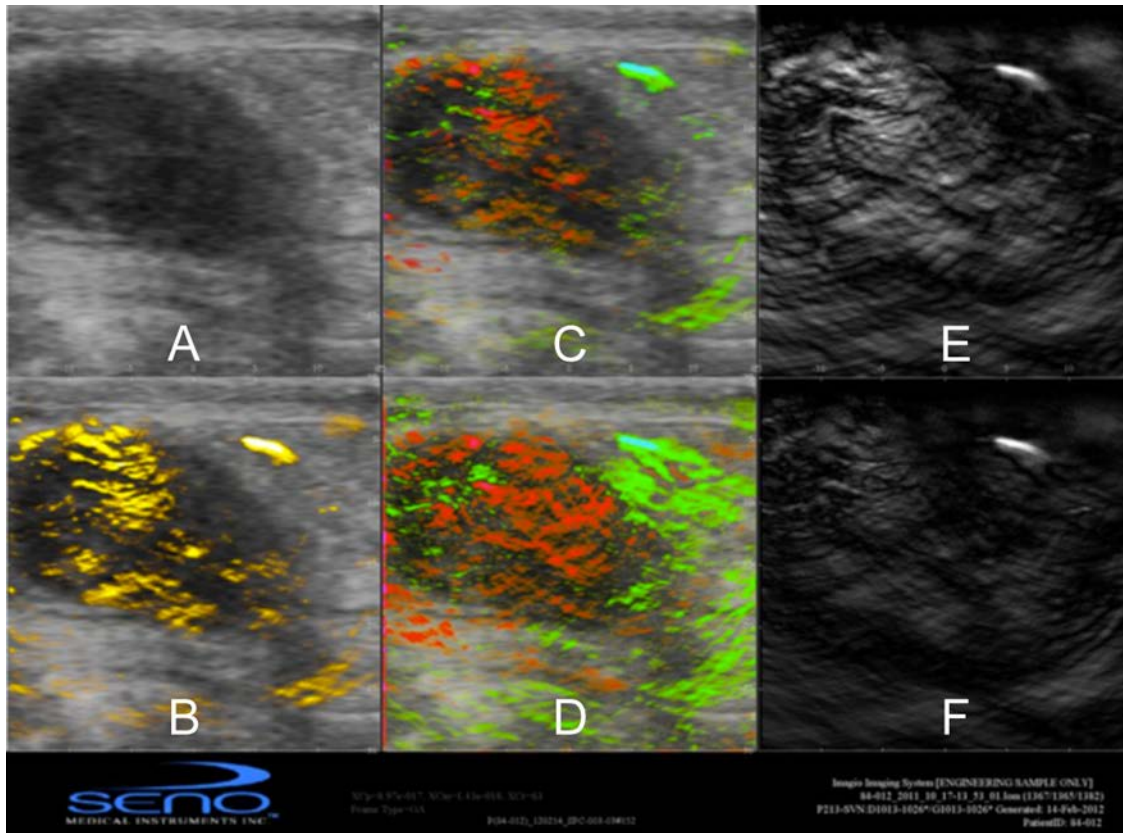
The Imagio 6:1 display: A. B-mode conventional ultrasound image shows oval mass with partially circumscribed and partially indistinct margins. B. Total map showing the regions of greatest blood flow within the image indicates increased vascularity within the tumor interior. C. Combined map showing the level of oxygenation within the regions of greatest blood flow reveals the hemoglobin within the tumor vessels to be deoxygenated, color coded as red. D. Relative map shows the relative degree of oxygenation within the imaged region. Information contained in the relative map is synthesized from the gray scale OA short wavelength (E) and and gray scale OA long wavelength (F) maps.
